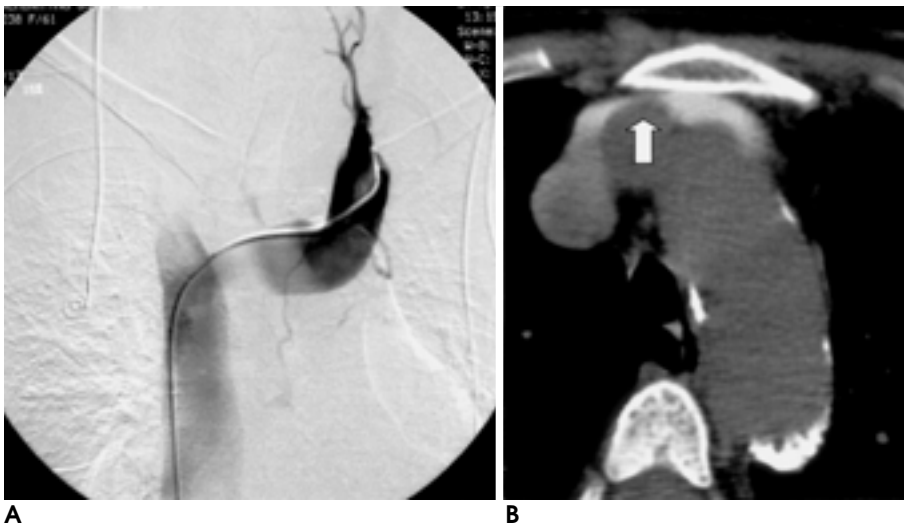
A. Post-balloon angioplasty venogram shows marked stenosis of the innominate vein due to extrinsic compression. B. CT angiogram shows the left innominate vein is compressed between sternum and right innominate artery (arrow).
